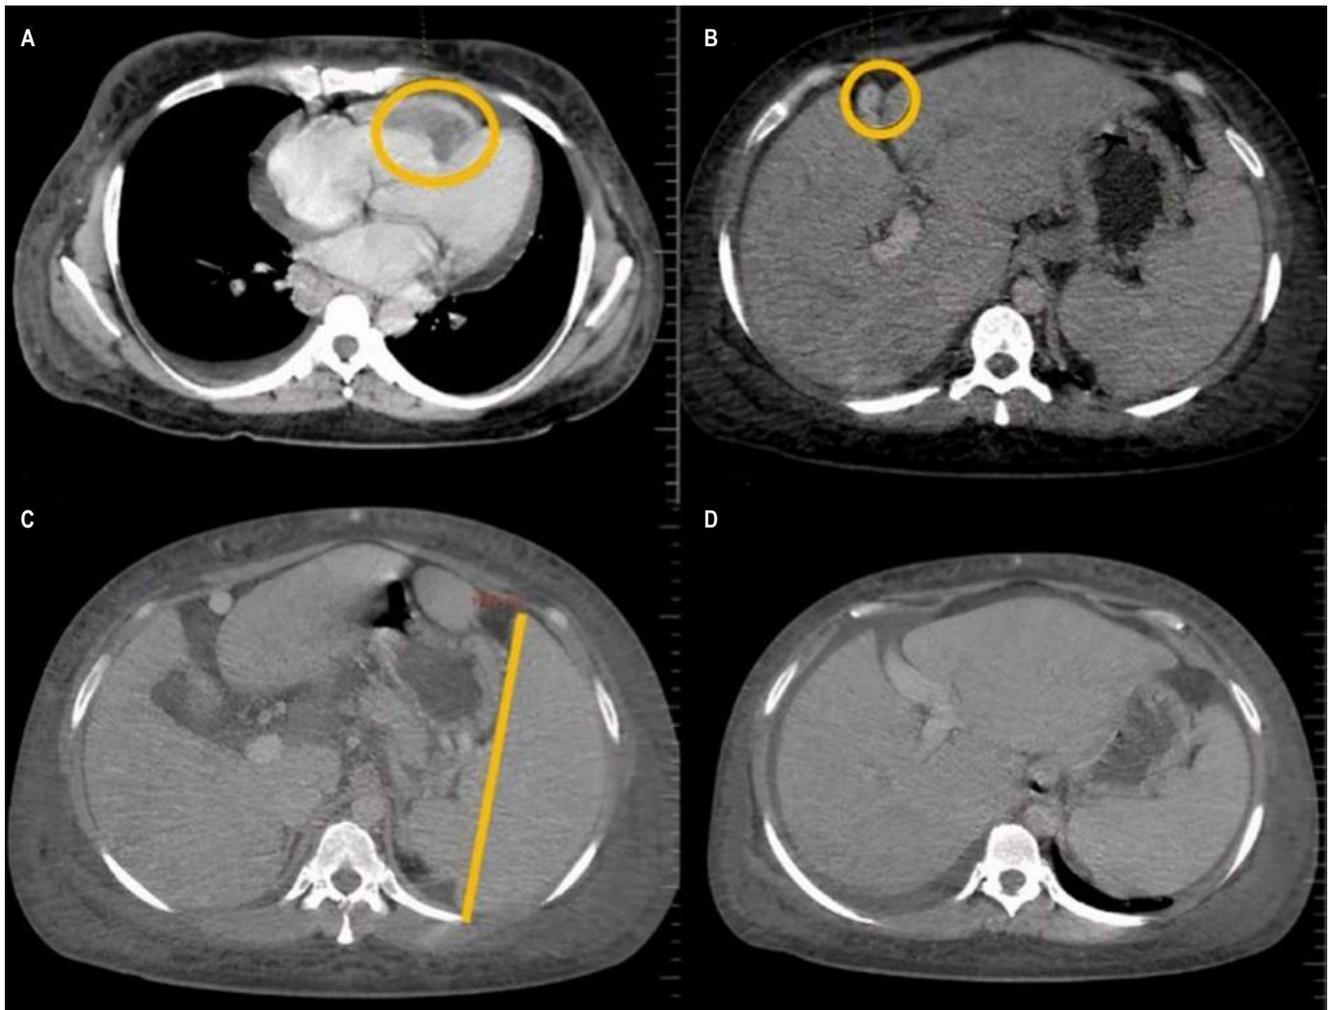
Contrast CT revealing: A. Right atrial thrombosis; B. BCS detected by the absence of blood flow at the level of the outflow tract of the middle suprahepatic vein, hepatomegaly; C and D. Splenomegaly, ascites, and collateral circulation. Courtesy of the radiology department, Hospital Regional de la Orinoquia (HORO).
